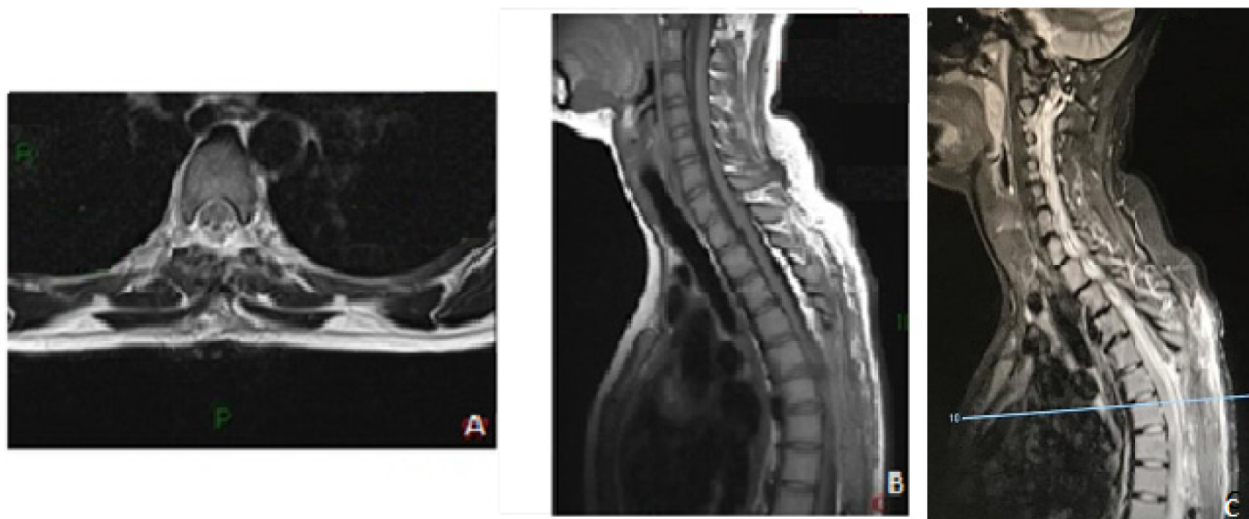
Two month post operative T2-weighted axial MRI (A), T1-weighted sagittal MRI (B) T2-weighted sagittal MRI. Note the complete removal of the cyst.
